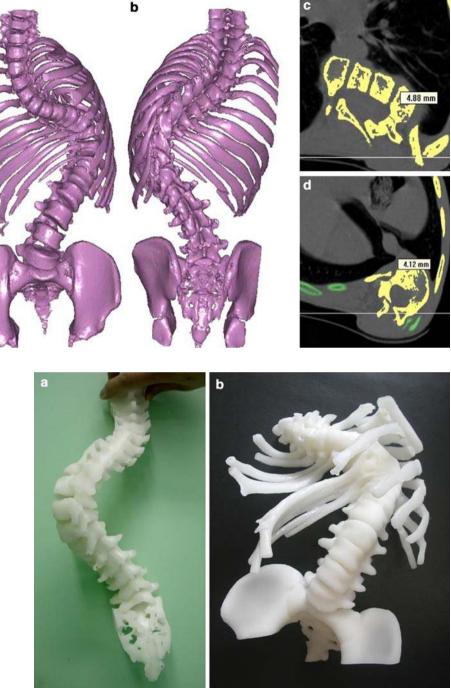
Digital spinal threedimensional reconstruction result based on the CT data set. a, b Spinal deformity can be viewed from any perspective. c, d The vertebral pedicle direction and diameter can be easily measured in plane from any angle on the personal computer with Mimics 6.3 software а
